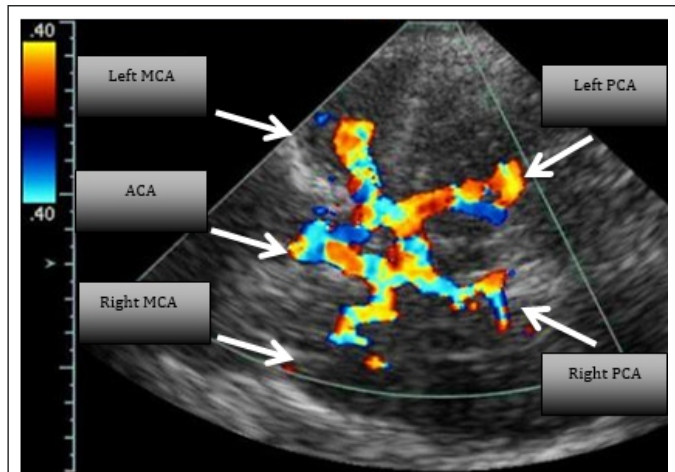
TCD is non-invasive method that uses pulsed-wave Doppler ultrasonography to measure blood flow velocity in the main branches of the anterior Willis Circle.
